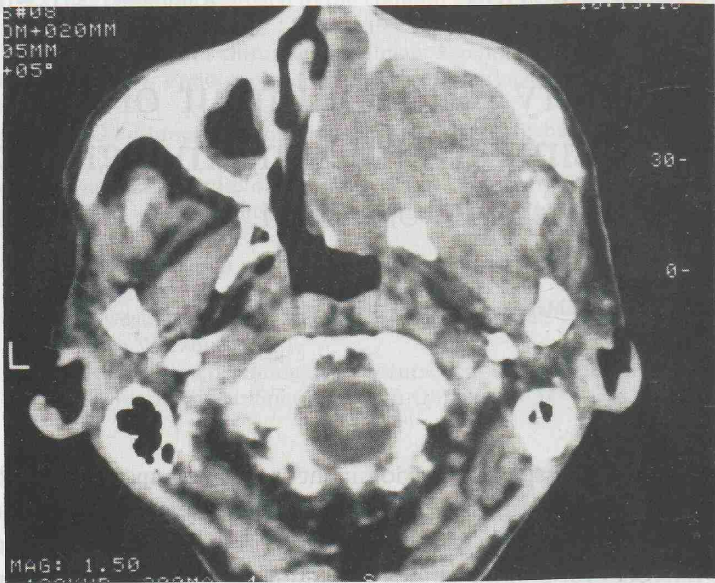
CT scan showing a pseudotumour filling the right antrum and nasal cavity with extensive bone destruction.
